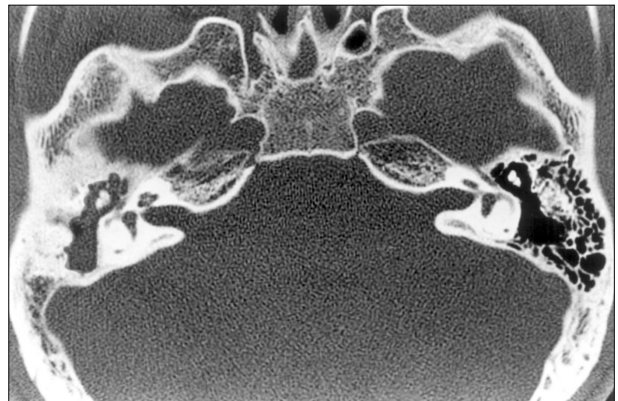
Temporal bone CT axial view in adult cholesteatoma shows relatively poor pneumatization of the diseased side.
